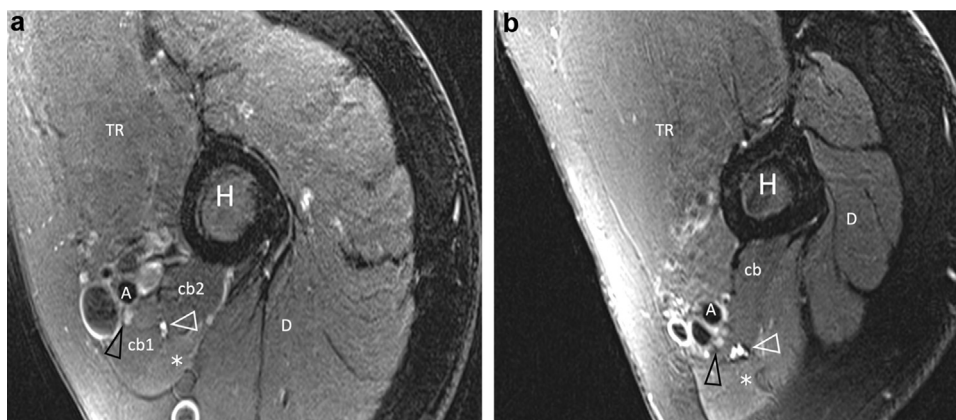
Axial MR image, T2-weighted sequence with chemical-shift fat saturation obtained at two different levels of the affected arm, at the proximal one third (image a) and between proximal and middle third (image b). The musculo-cutaneous nerve (white void arrowhead) is seen in between the two heads of coracobrachialis muscle (cb1, cb2) in a and in between the biceps (white asterisk) and coracobrachialis (cb) muscles in b; the nerve appears swollen and with hyperintense fascicles respect to the median nerve (black void arrowhead). The hyperintensity of fascicles is a typical feature of inflammatory process involving the nerve and is related to intraneural oedema; in the Neuralgic Amyotrophy the pathologic changes are multifocal, as demonstrated by the different size of musculo-cutaneous nerve in a and in b. The biceps muscle (white asterisk) is slightly hyperintense due to denervation-related intramuscular edema. TR=triceps muscle; D=deltoid muscle; A=brachial artery; H=humerus.
